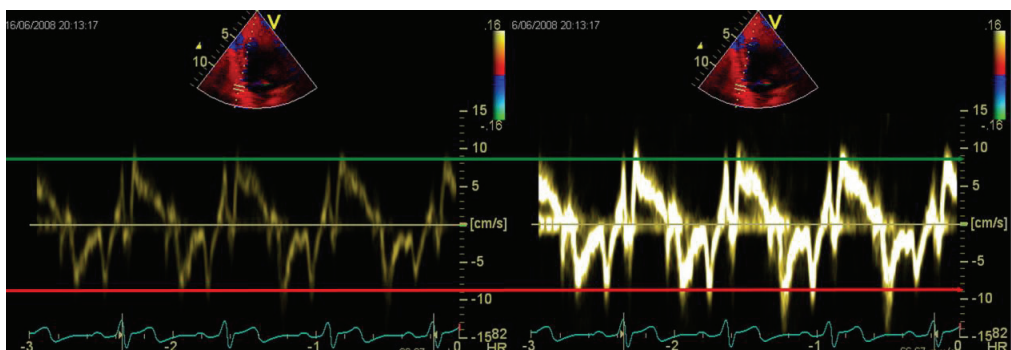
Pulsed wave TD assessed velocities from the base of the inferior LV wall with low gain settings in the left recording and the high gain settings in the same recording at right. Green line refers to peak systolic velocity measured at the outer edge of the Doppler spectrum at low gain, and with high gain it is obvious that similar method measure higher velocity. Red line refers to peak early diastolic velocity at low gain, and similarly it looks like the velocities are higher when gain is increased. The alignment of the beam with the myocardial wall is not optimal, but within the advised 15-20 degrees.
